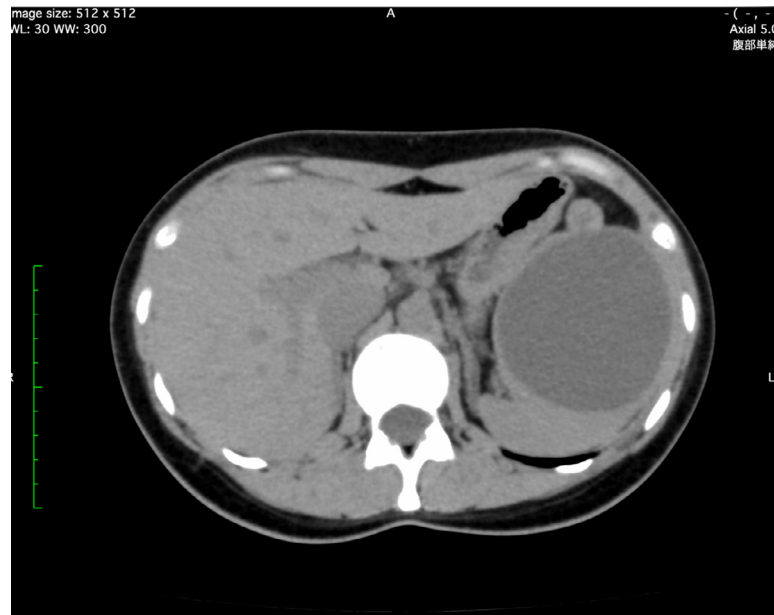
Computed tomography performed 3 months after sclerotherapy shows a significant reduction in the size of the cyst.
